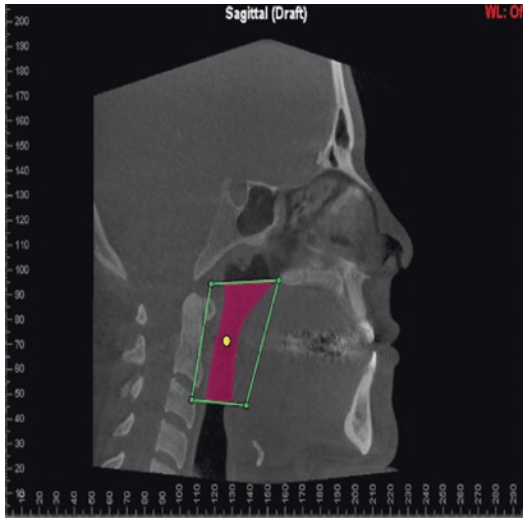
Volumetric analysis of CBCT. (Courtesy of Dr. Joseph Ivory)
